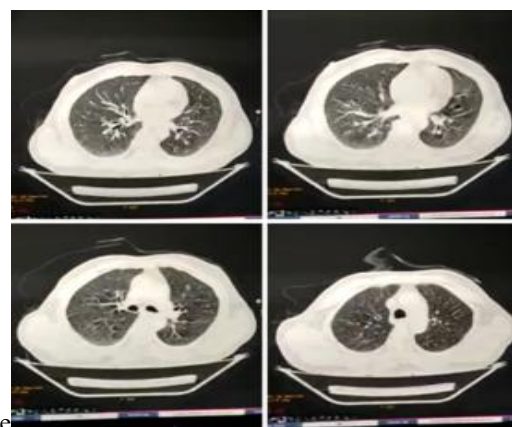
CT scans of the chest (Image 3b)
